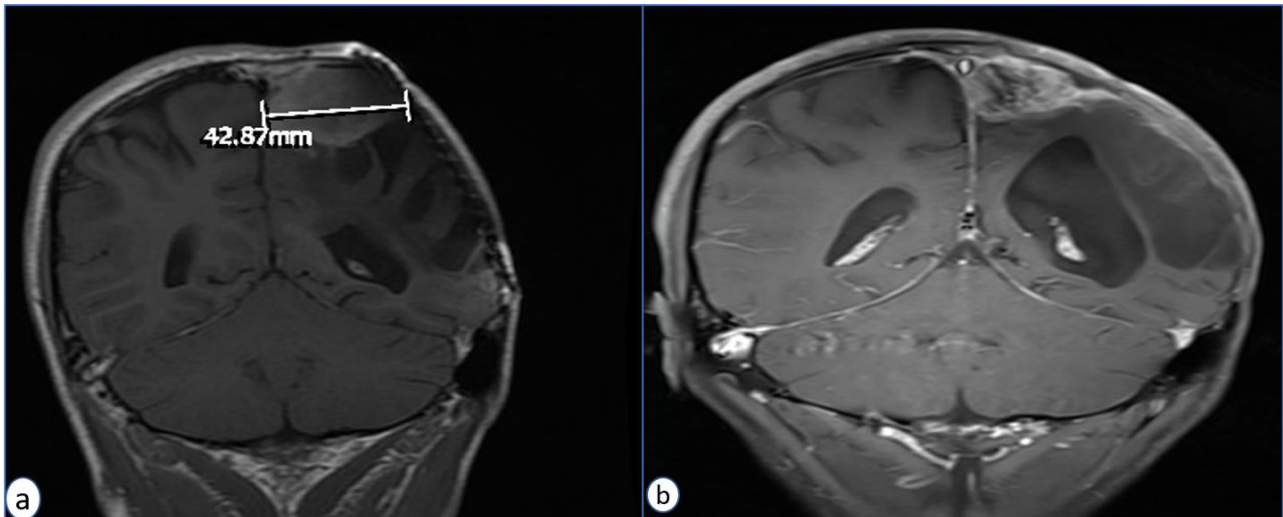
(a) MRI scan, T1 with contrast coronal cut showing significant interval progression of the known residual nodules in the left hemisphere measuring at least 4 cm at maximum diameter. (b) MRI scan, T1 with contrast coronal cuts showing further progression of the tumor with evidence of central necrosis.
